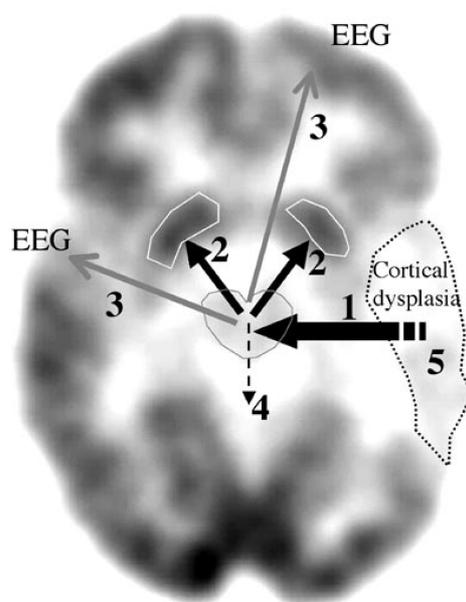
Putative cortico-subcortical circuitry activated during infantile spasms (15). 1: Cortical epileptic discharges from an area with cortical dysplasia (severe hypometabolism on FDG PET) triggering the brainstem, presumably the dorsal raphe area, a brain region with large number of serotonergic cell bodies; 2: Bilateral, serotonergic raphe-striatal projections activate the striatum; 3: Raphe-cortical interactions induce multifocal discharges on the EEG; 4: Propagation to the spinal cord can lead to symmetric spasms; 5: Surgical resection of the primary offending lesion (focal cortical dysplasia) can alleviate the spasms by preventing the circuit from being activated
